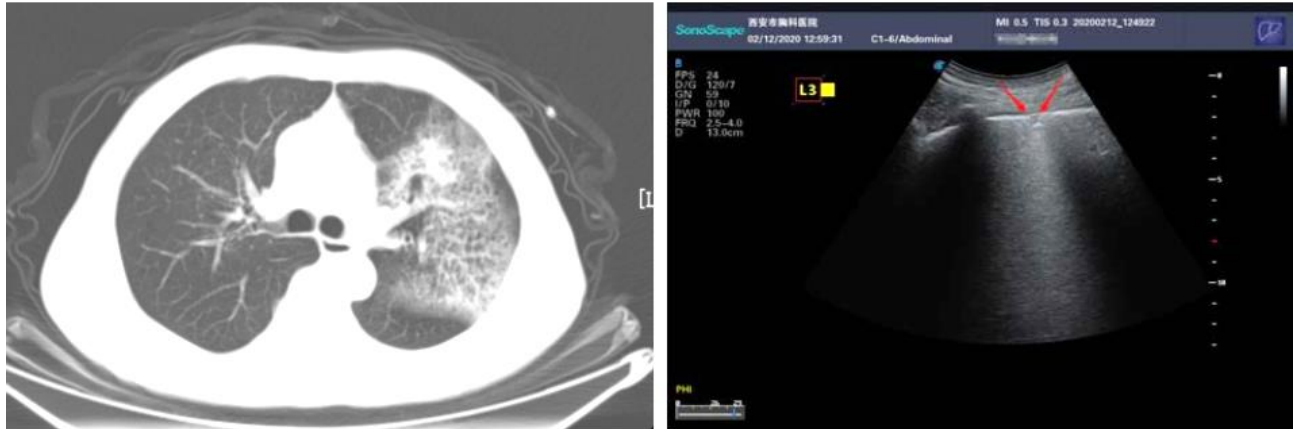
Chest high-resolution computed tomography (HRCT) (left) showed GGO and reticular shadows under the pleura in the field of the left lung. The convex array probe (right) revealed B lines in the left posterior lower area and a line disappeared. Small patchy lesions were observed and the pleural line was discontinuous (red arrow) (Huang et al., 2020c).
